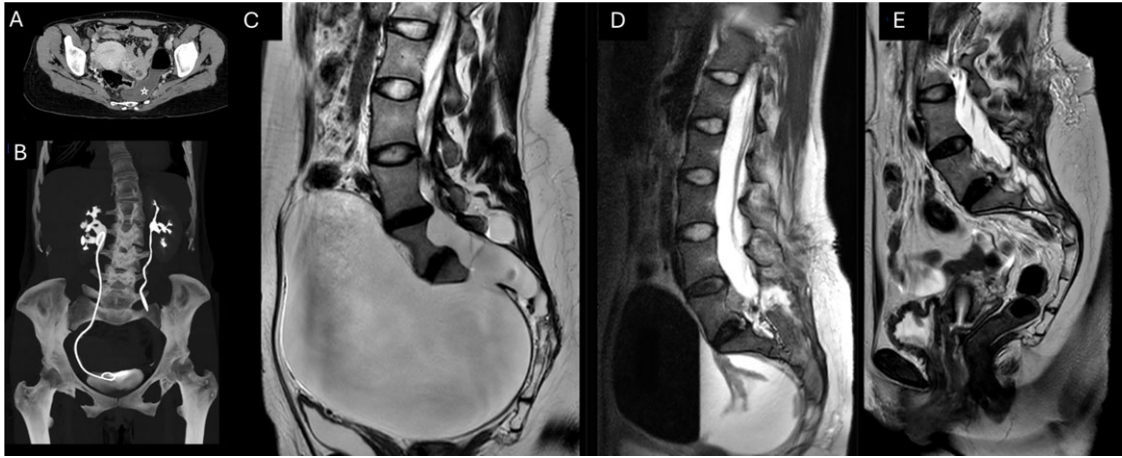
(A) Postoperative CT of the abdomen and pelvis acquired 3 months after surgery. Partial resorption of the meningocele, with air-fluid level, residual in the presacral space (void star), and relocation of the pelvic organs. (B) Coronal maximum intensity projection reconstruction showing partial resolution of the right side hydronephrosis, with a ureteral stent in place, and complete resolution of the dilatation of the left ureter. Sagittal T2-weighted sequences showing the temporal evolution of the meningocele (C) before surgery, (D) after 3 months and (E) after 9 months.
